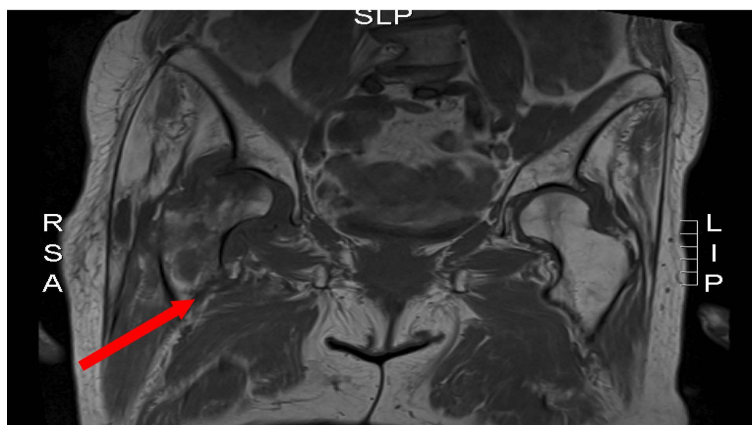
MRI, one month later.
